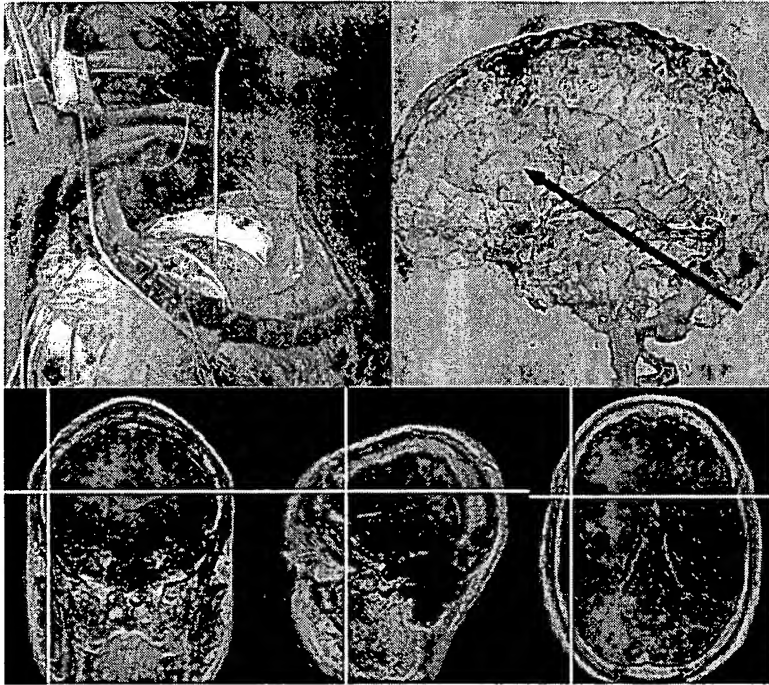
Image-guided neurosurgery planning and navigation system developed by MIT and Brigham and Women's Hospital. (*Upper left*) Photograph of operative field after craniotomy; optical markers on the hand-held probe at the center enable tracking and registration. (*Upper right*) Perspective view of segmented MR image data. Colors indicate normal (*gray, red, blue*) and pathological (*green*) brain structures. *Blue arrow* indicates probe location determined from real-time tracking data. (*Lower images*) Orthogonal views through MR data. Crosshairs show current probe tip location to assist in navigation. (Reprinted with permission from WEL Grimson, MIT.)
